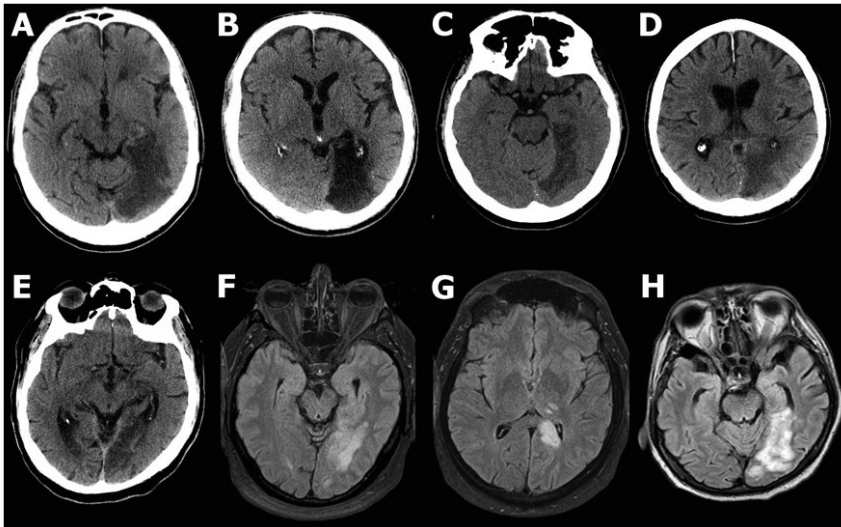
Patients' brain imaging data (computed tomography or magnetic resonance imaging) showing the location of stroke.
